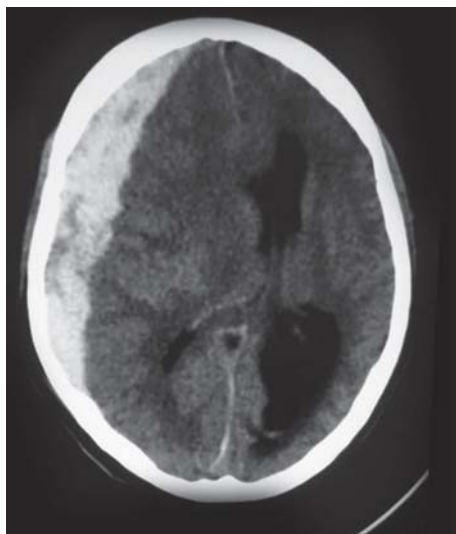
CT scan showing subdural hematoma
